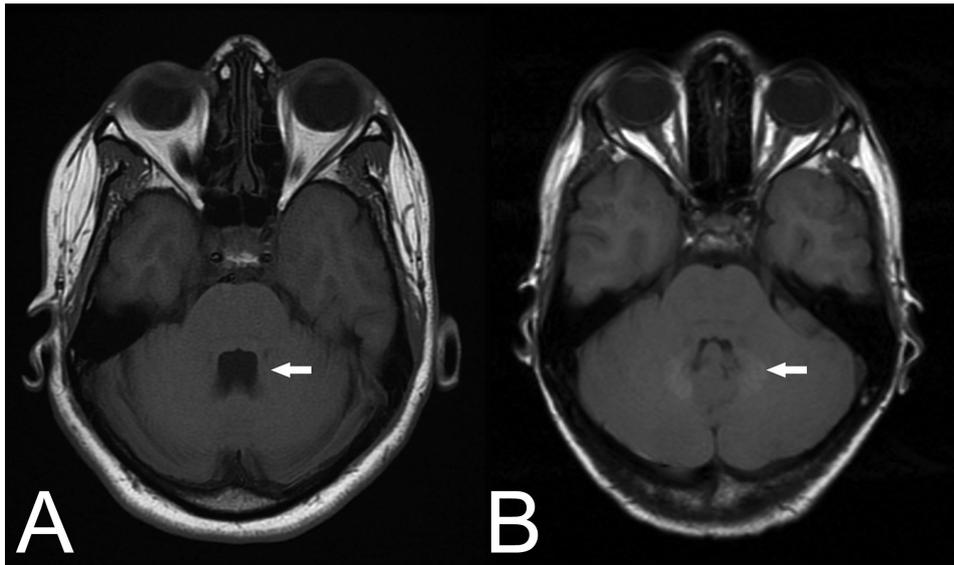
A: Normal T1-weighted axial scan through the posterior fossa demonstrating low signal in the dentate nucleus. B: T1-weighted non-contrast axial scan demonstrating high signal of the dentate nucleus
